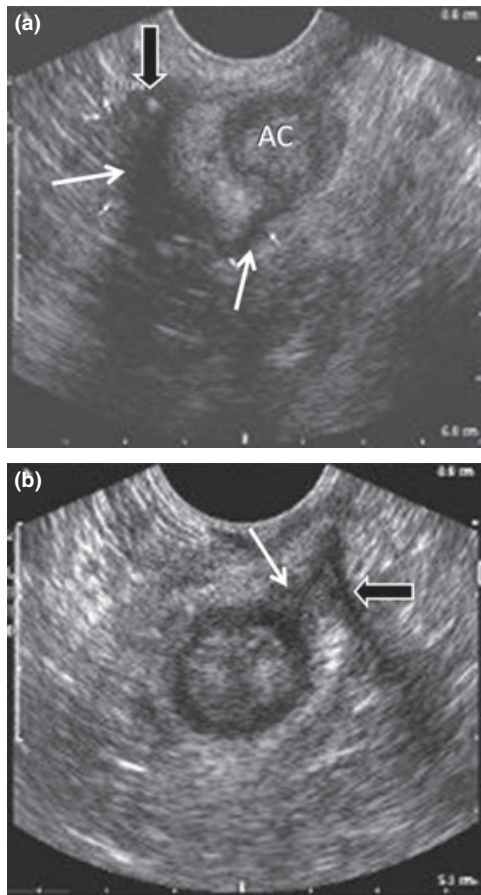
(a) Posterior internal opening site on transperineal ultrasonography axial image in a patient with anal canal stenosis where an endoanal ultrasound probe could not be deployed. The fistula (arrows) is shown clearly entering the anal canal (AC) posteriorly in the midline. In this case a hyperechoic seton is also identified (block arrow). (b) Anterior internal opening site seen on transperineal ultrasonography axial image (arrow) coursing laterally into the ischiorectal space (arrow-head).
